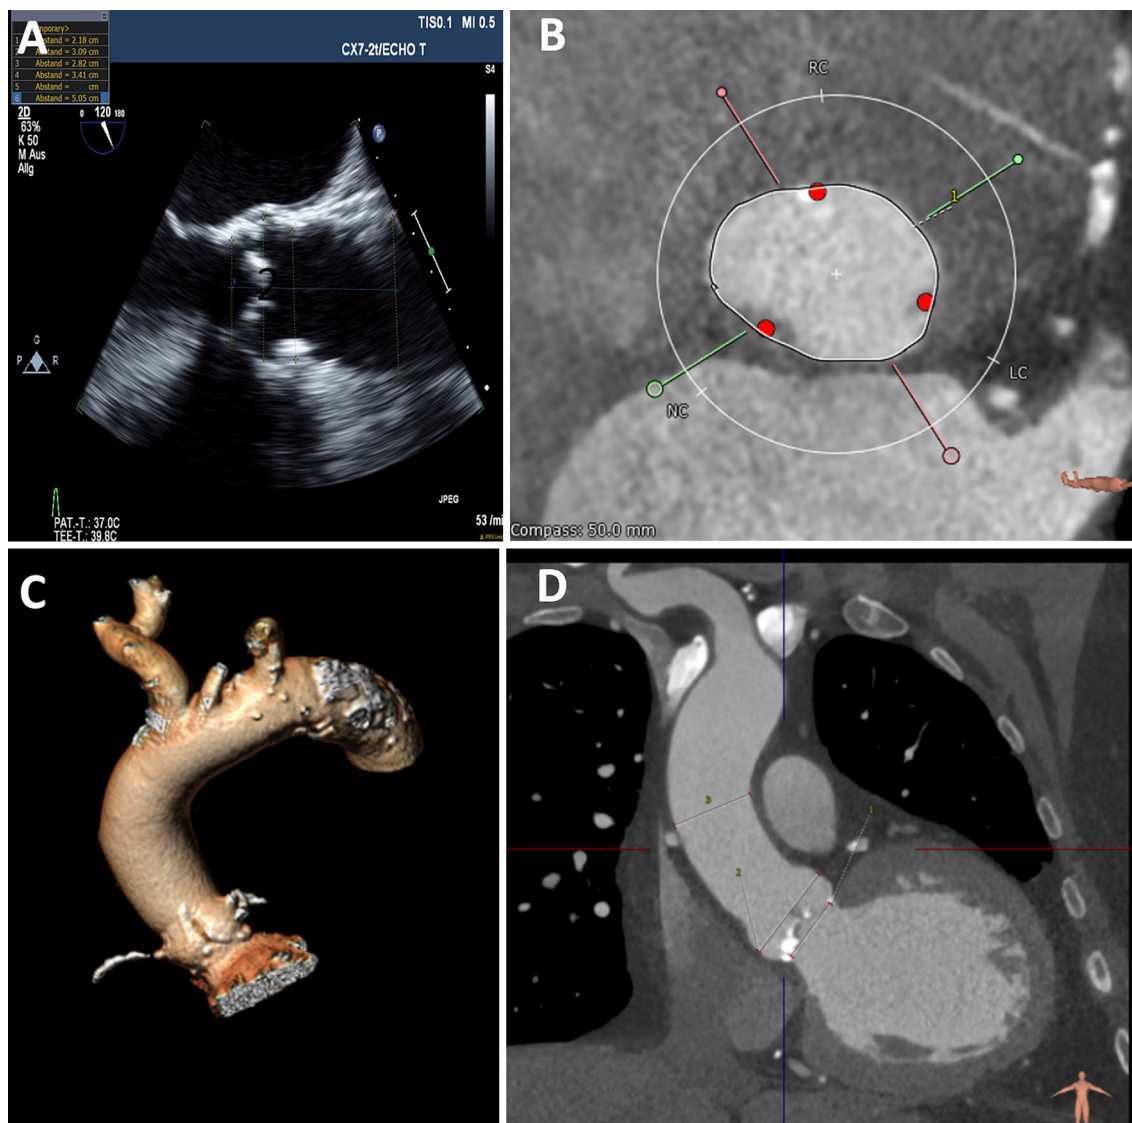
Multimodality imaging of the aortic annulus. The annulus may be imaged using the 120°–140° long-axis view (3-chamber view) in transesophageal echocardiography (a) or using multidetector computed tomography (MDCT) (b–d). The virtual annulus is
